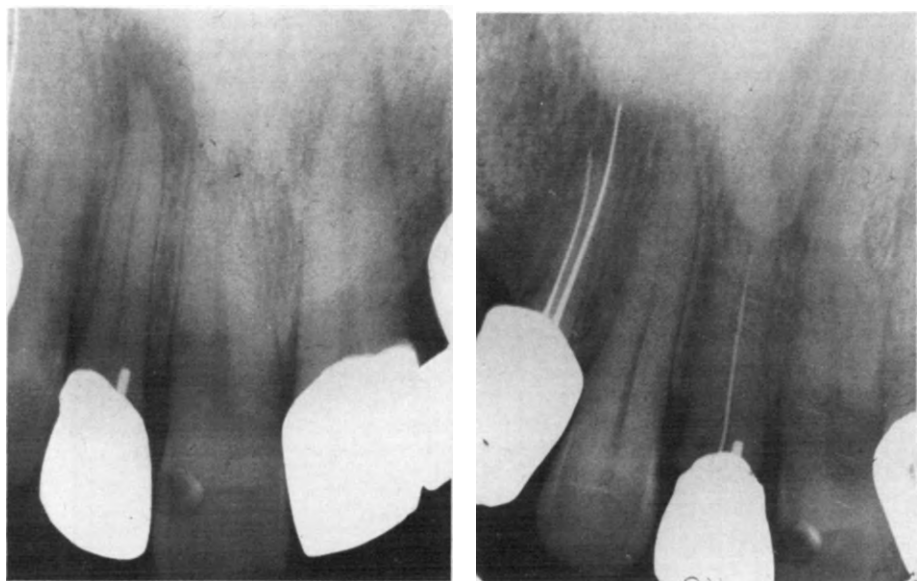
Shows effects of adding or subtracting mineral bone content in establishing radiolucency. Left, apical lesion in maxillary second incisor becomes obliterated in radiograph on right because of superimposition of torus palatinus. Increase in thickness and higher bone density of torus has masking affect on lesion in left radiograph, by increasing amount of mineral in path of X-ray beam, thereby reducing percentage of MBL.
